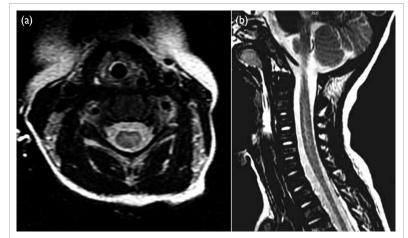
Axial (a) and sagittal (b) images on T2-weighted magnetic resonance imaging of spine showing mild T2 hyperintensity with mild expansion within central portion of cervical cord from C3 to C6
